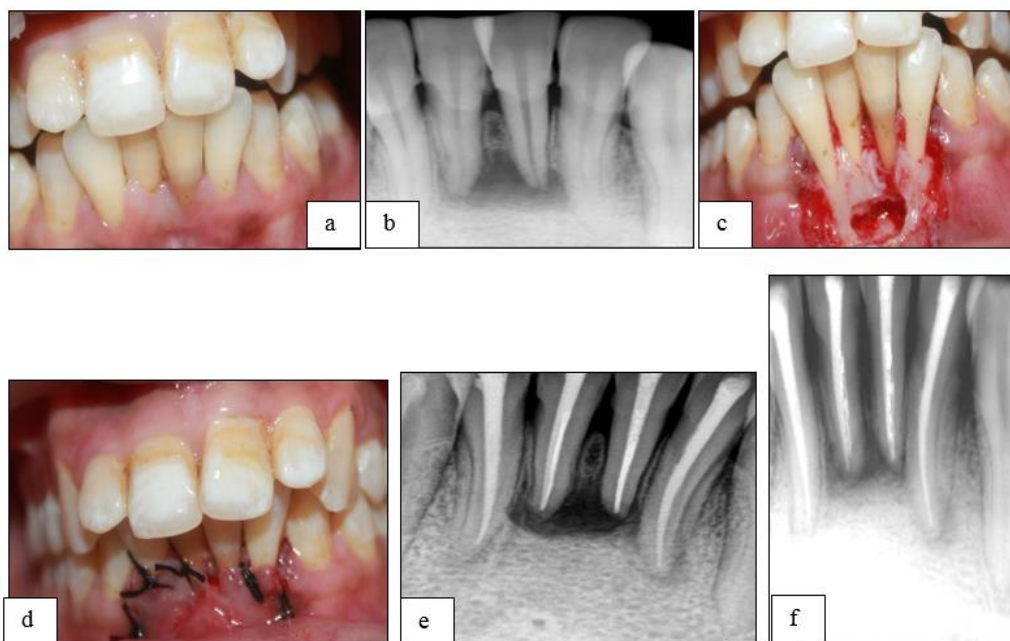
Preoperative #41; b: Preoperative radiograph; c: Flap raised to expose the defect; d: Suturing done; e: Post-obturation radiograph
